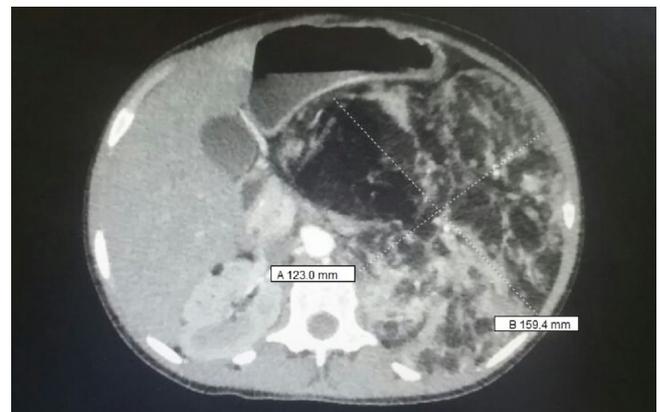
Axial image from a contrast enhanced computed tomography (CT) shows a primarily fat containing mass arising from the left kidney suggestive of a giant angiomyolipoma (Hounsfield units of $-68,97$).
